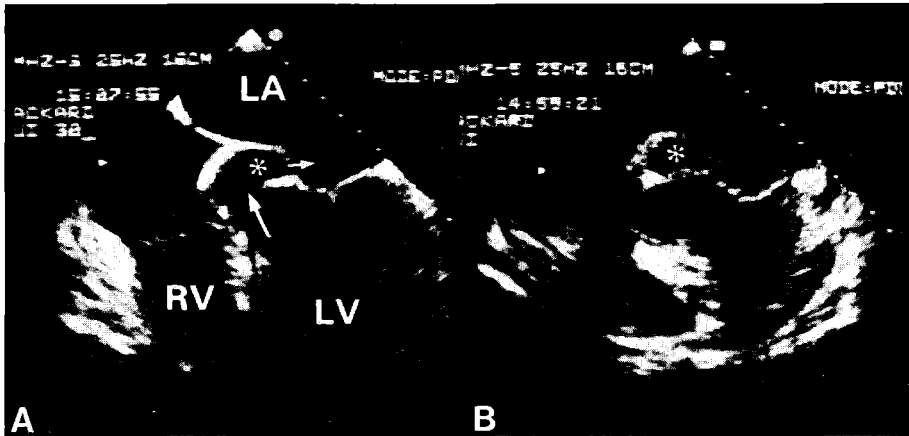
Transesophageal echocardiographic systolic still frame (A, B) from a patient with native mitral valve endocarditis (Table I, case 12). A, A subannular (to the aortic junction) mycotic aneurysm (asterisk) with a fistulous connection of the left ventricular outflow tract (large arrow) via the aneurysm into the left atrium (LA, small arrow). B, Slight superior tilting of the transducer showed there was communication between the aneurysm and left ventricle or left atrium. LV = left ventricle; RV = right ventricle.
